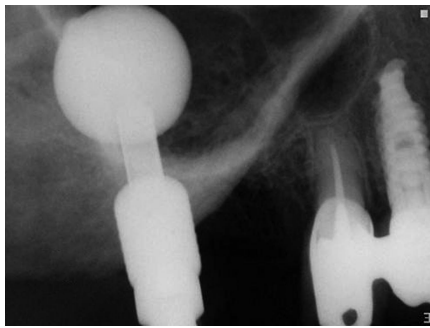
Periapical radiograph 6 months postsurgery.
